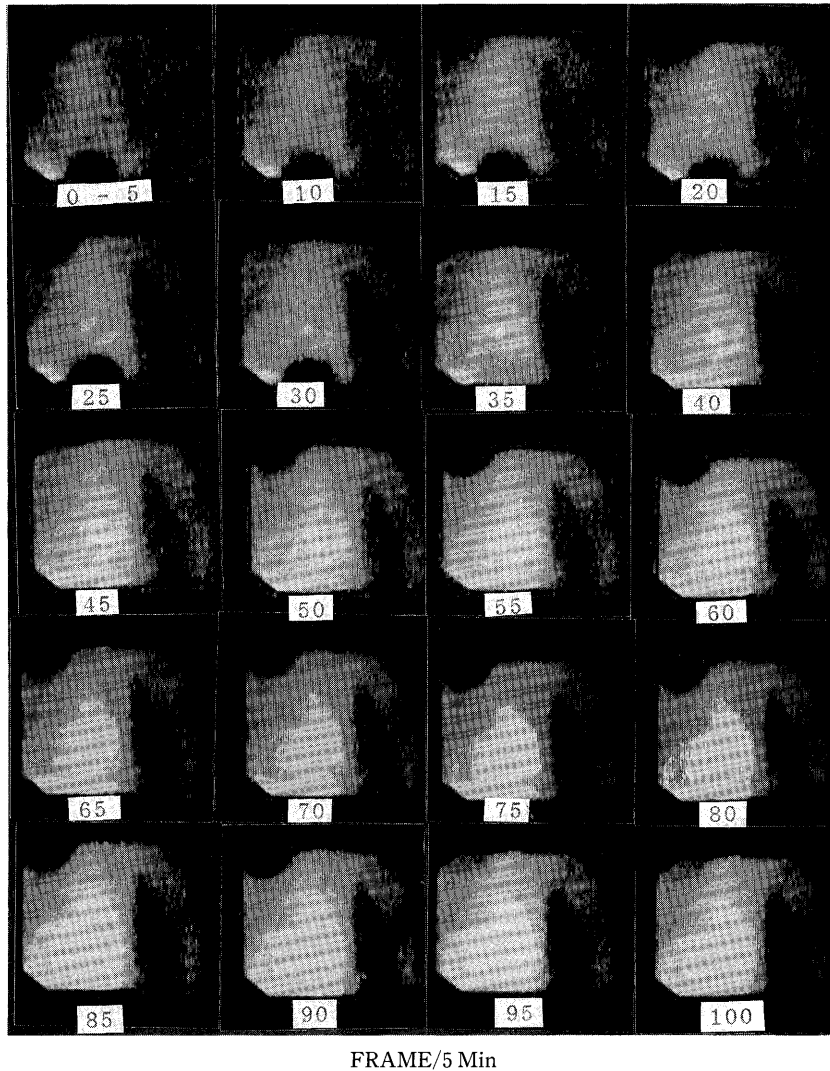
Sequential scintigrams after transrectal administration of MIBI in a patient with liver cirrhosis with portal-systemic shunt. Heart, lungs, spleen, and stomach were observed.
